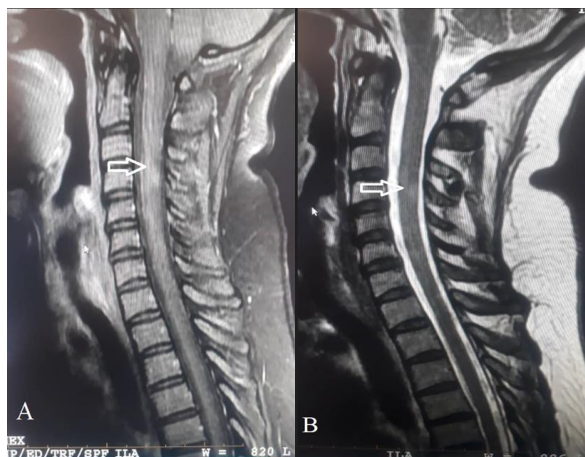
Demonstration of MS plaques using sagittal STIR (A), sagittal T2-W (B); as you can see, the cervical spinal cord plaques are more evident in the FLAIR sequence
